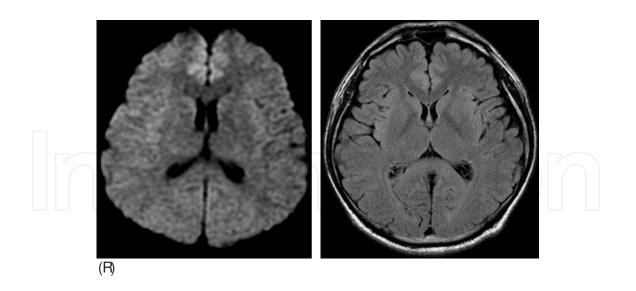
MRI DW & FLAIR images revealed high intensities at the cingulate gyri in a 32-year-old man with status epilepticus-type FluE (influenza-associated encephalopathy).
